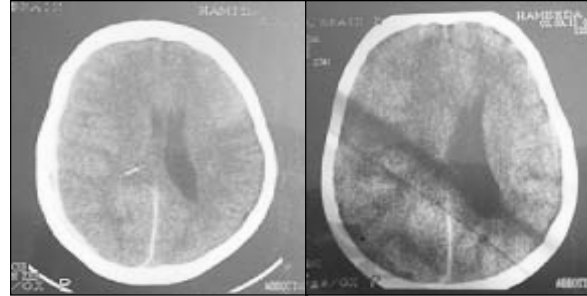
CT Scan of a patient showing hyperdense shadow on right side which changes into hypodense shadow with significant midline shift suggesting acute SDH changing into chronic SDH.
